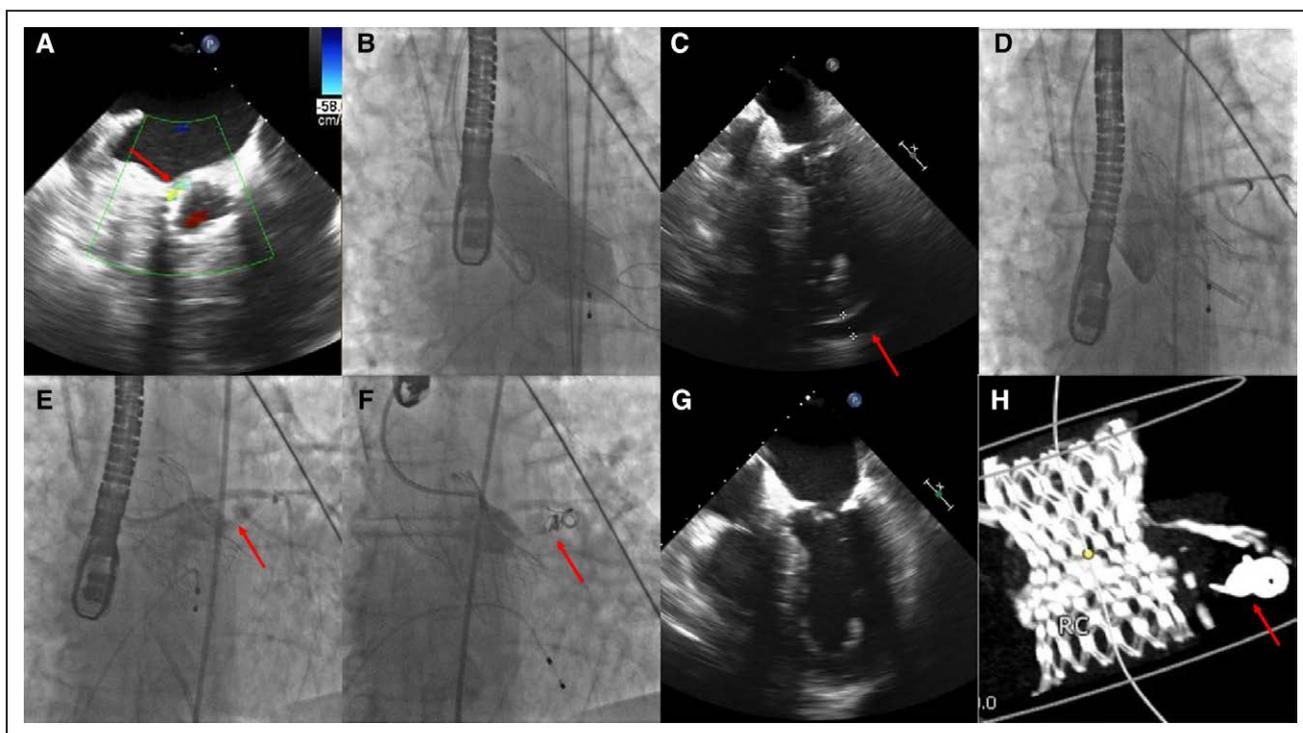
Coiling of the periaortic space created by the root rupture occurring during Evolut R valve implantation. A, Moderate paravalvular aortic regurgitation (arrow) after Evolut R valve implantation. B, Post-dilation performed with a 26 mm×4.5 cm Z Med II balloon. C, Cardiac tamponade immediately after post-dilation (arrow). D, Nonselective aortic root angiogram did not reveal the site of aortic root rupture. E, The site of aortic root rupture noted on selective angiogram of the left coronary cusp (arrow). F, Successful closure of the site of aortic root rupture with 2 MReye Embolization Coils (arrow). G, Final echocardiogram with no residual pericardial effusion. H, Coils outside the left coronary cusp noted on computed tomogram performed after transcatheter aortic valve replacement.
